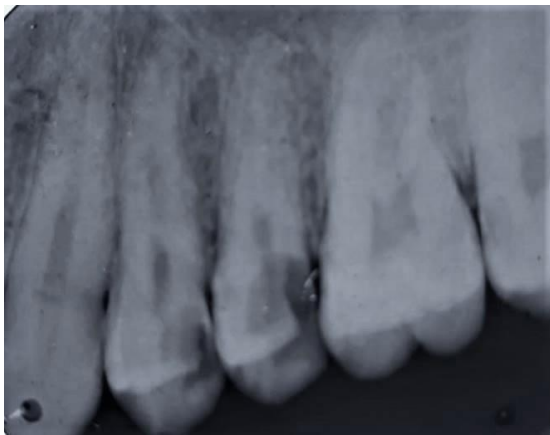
Preoperative radiograph showing greater MD width& a fast break for 24
